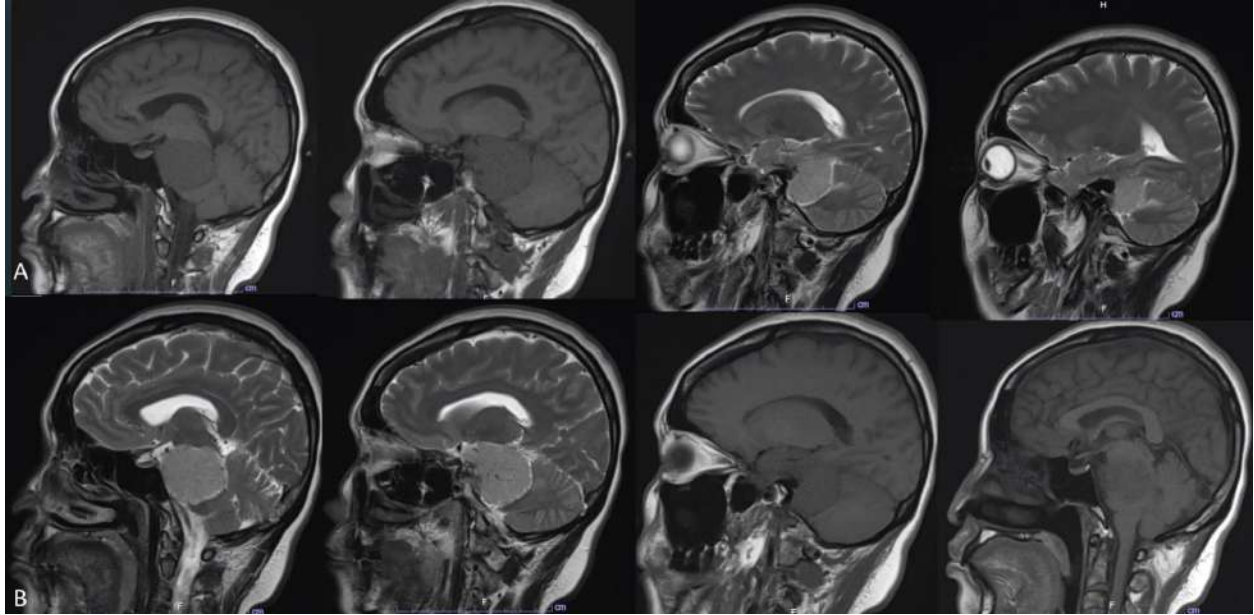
MRI IAC with Inner Ear. *1A*: Axial view of the T1WI, *1B*: Axial view of T2WI.
